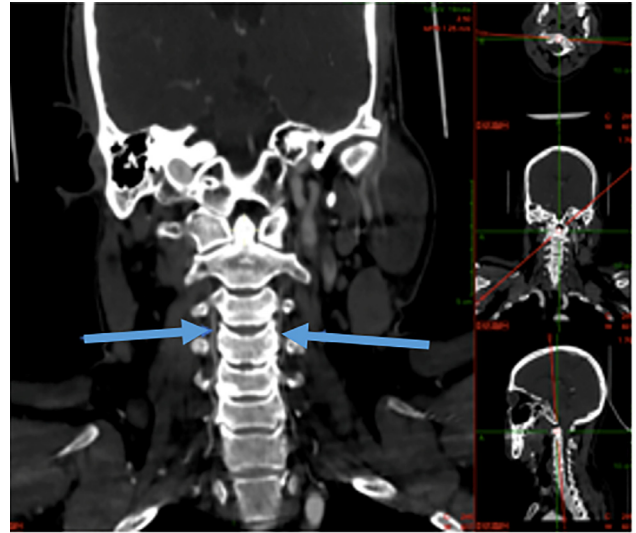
Coronal CT brain and neck angiogram shows vertebral arteries are hypoplastic arrows.
